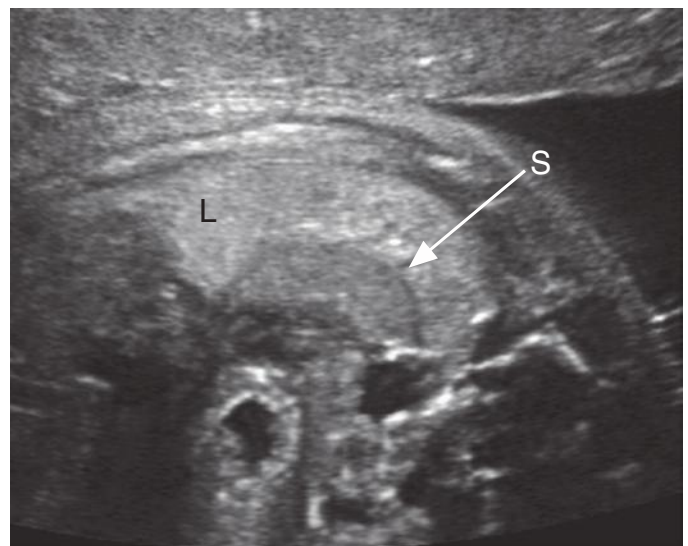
Transverse sonogram of the left fetal hemithorax with congenital diaphragmatic hernia demonstrates that the spleen (S) within the chest is well differentiated from and less echogenic than the adjacent fetal lung (L).
